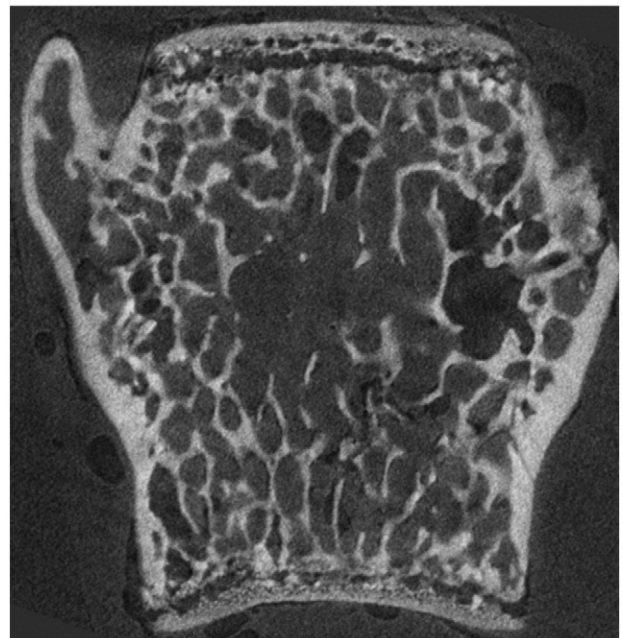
Coronal section of a thoracic vertebral body, obtained with microcomputed tomography.
